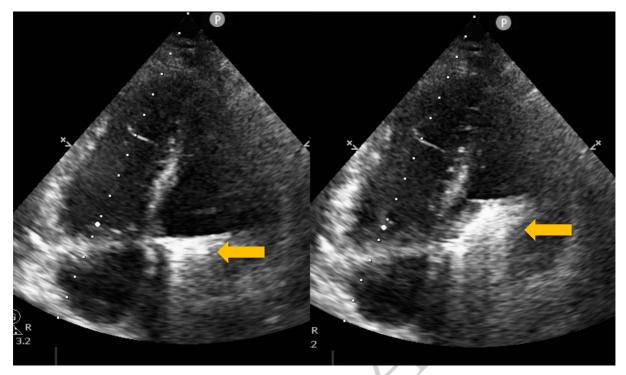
Right. Four chamber view echocardiogram in systole showing a hyperechoic lesion related to anterior leaflet of the mitral valve (arrow). Left: Redemonstration of the mobile hyperechoic lesion related to the mitral valve in diastole.
